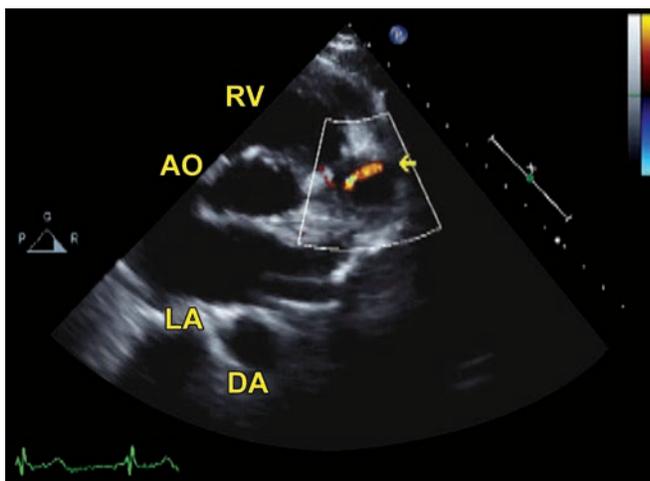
2DTTE. Color Doppler demonstrates flow signals in the space (arrow) predominantly in diastole.
